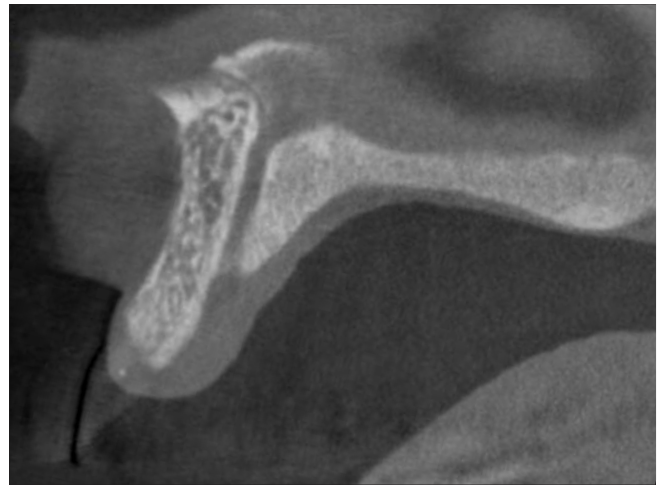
Sagittal CBCT slice
